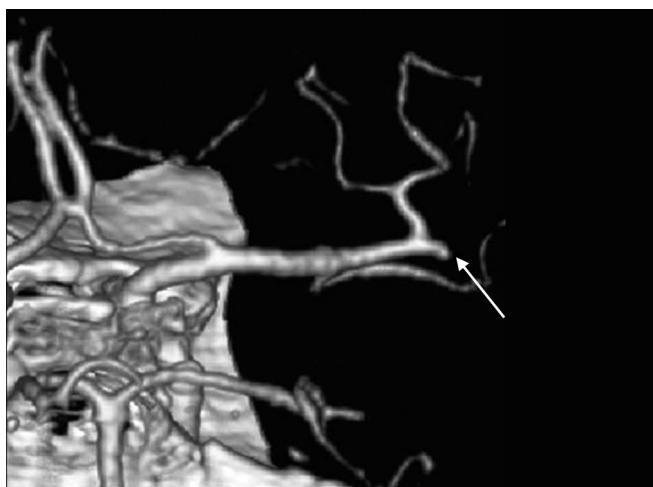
Computed tomography angiography in posterosuperior view showing complete occlusion of the inferior division of the right middle cerebral artery (MCA) (arrow)
